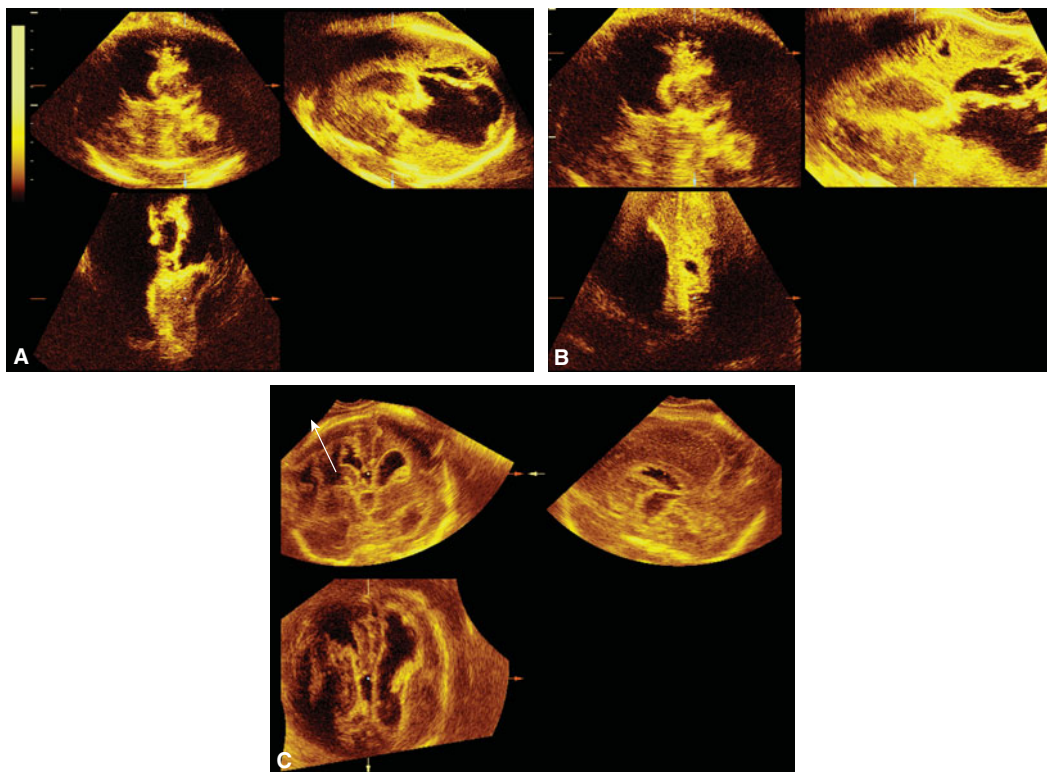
Porencephalic insult to the fetal brain imaged using three-dimensional (3D) transvaginal ultrasound (US). Observe the irregular anechoic spaces representing infarcted areas, as well as the dilated ventricles. Coronal (A), sagittal (B), and axial (C) sections.
